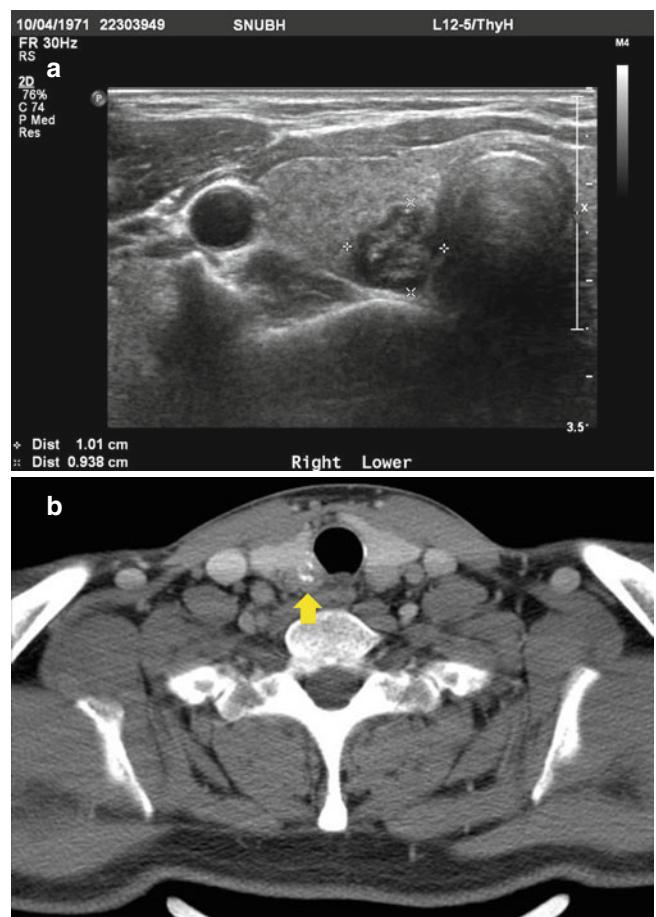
(a) USG of deep-lying carcinoma, (b) CT scan of deep-lying carcinoma
